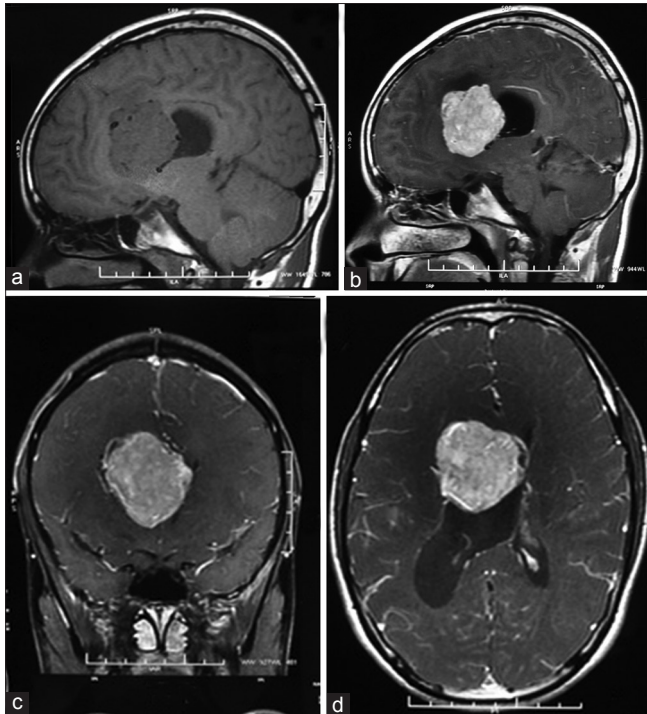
(a) T1-weighted MRI showing the tumor in frontal horn (b) T1 weighted sagittal MRI with gadolinium contrast showing well circumscribed tumor with intense enhancement (c) Coronal contrast MRI (d) Axial contrast MRI of the tumor showing the extension of tumor to opposite frontal horn and body
